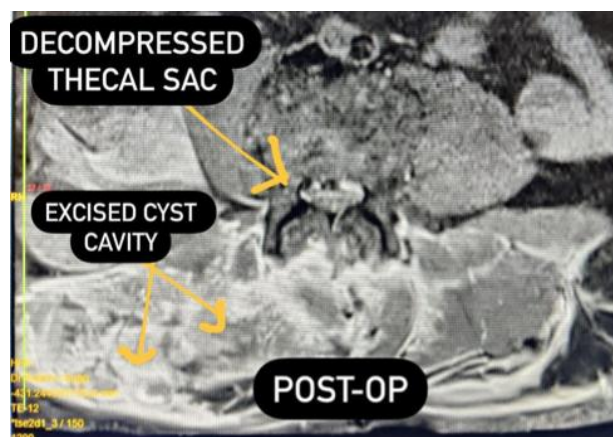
Post operative MRI scan (axial view)
